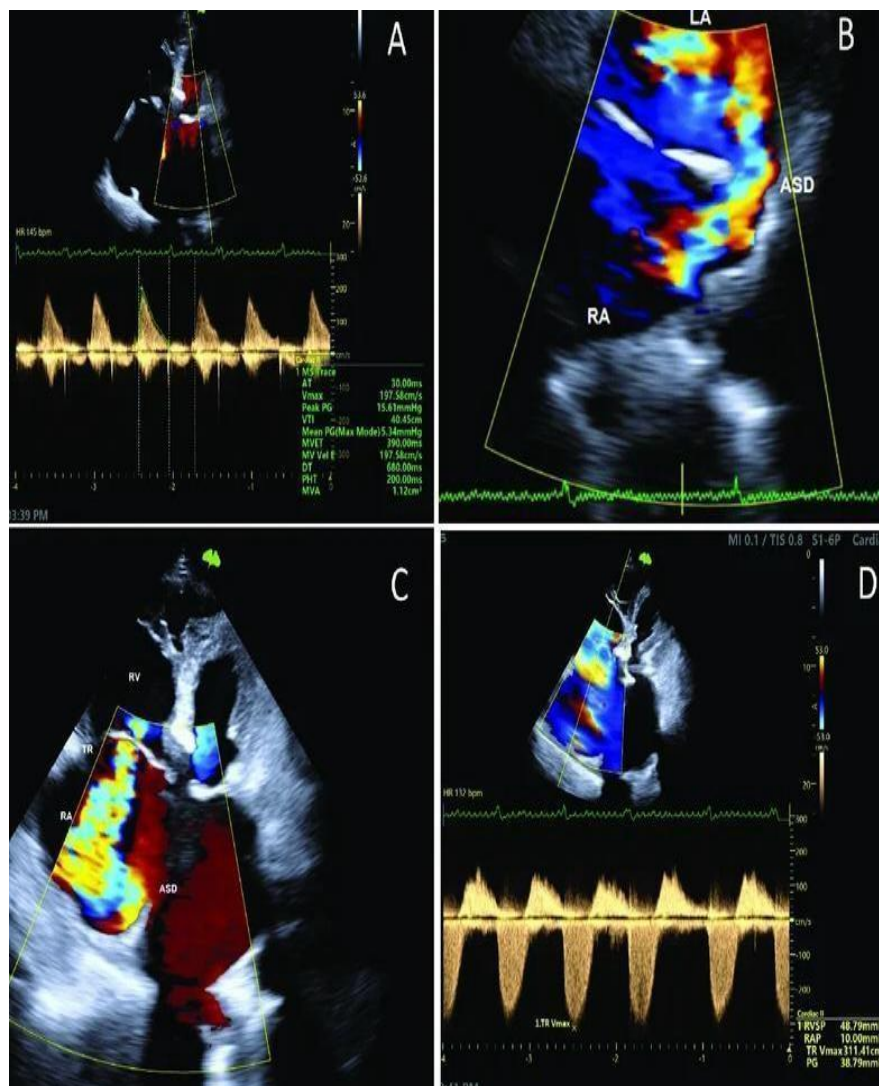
Transthoracic echocardiogram. A) Mitral stenosis gradient; B) ASD color doppler flow; C) Severe tricuspid regurgitation color doppler; D) Tricuspid valve continuous wave doppler signal.
